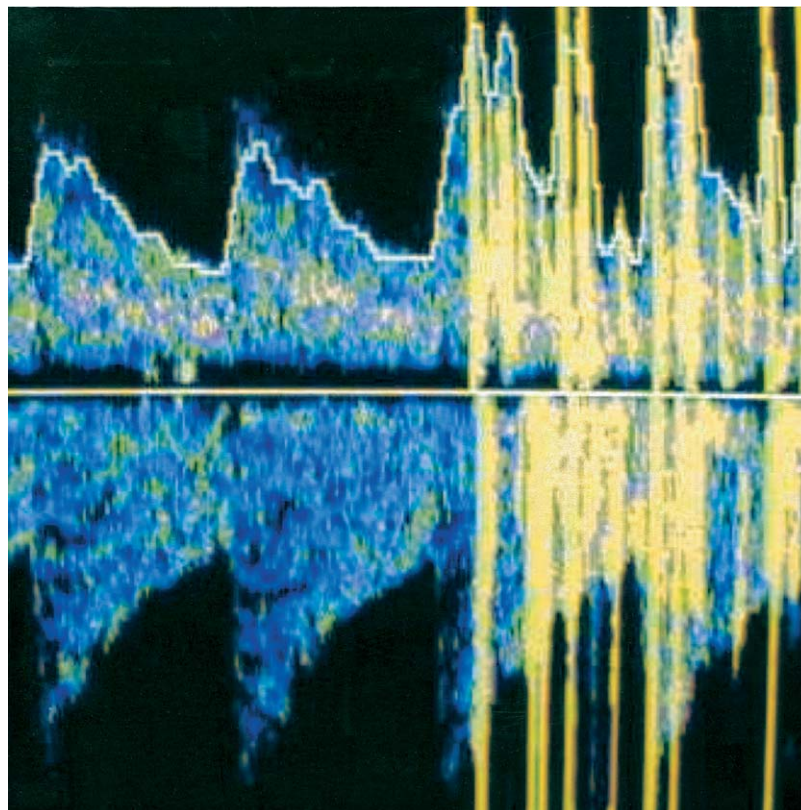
Characteristic appearance of microbubbles on a middle cerebral artery Doppler trace in a patient with a venous-to-arterial circulation shunt.
